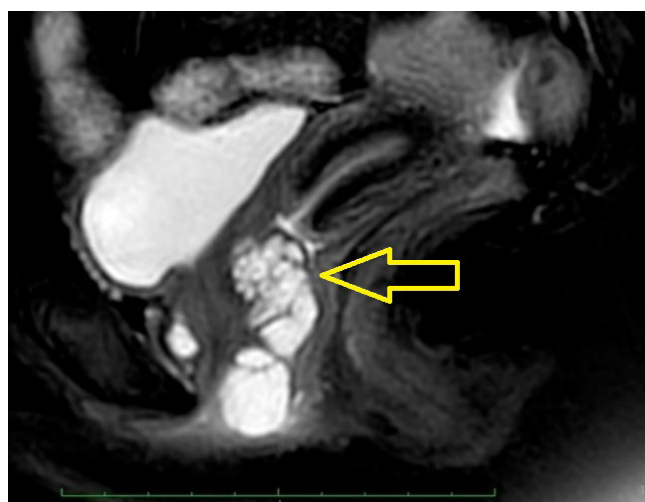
T2-weighted sagittal magnetic resonance imaging scan showing the diverticulum relative to the level of the bladder neck and urethra. The diverticulum extends anteriorly and posteriorly to the urethra.
